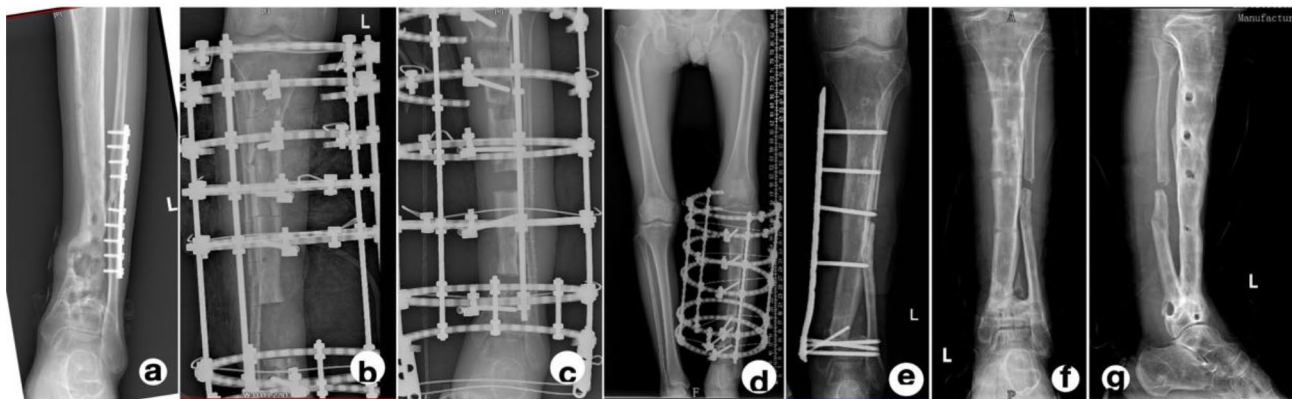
A 62-year-old male with a left tibial bone defect caused by FRI was treated with an LCP as a sequential external fixator following the distraction phase. (a) X-ray of left tibia before Ilizarov bone transport surgery. (b) Postoperative X-ray of the left tibia showed that DS after debridement was almost 6.6 cm. (c) X-ray of distraction phase. (d) The termination of the distraction phase and docking site was connected in the 10th postoperative week. (e) LCP as a sequential external fixator following the distraction phase, with an interval of 1.8 weeks. (f, g) Satisfactory bone result after 8.3 postoperative months
